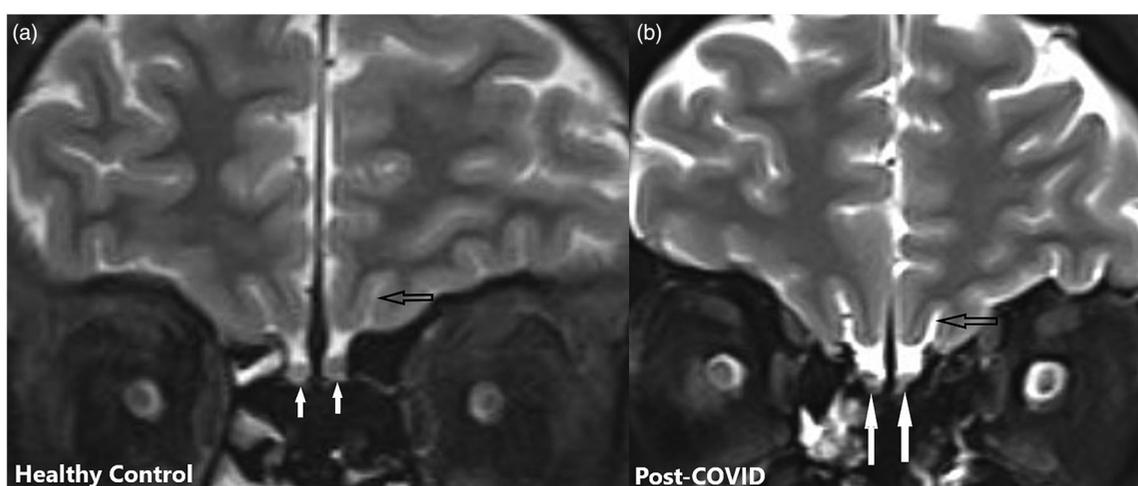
A healthy adult 43-year-old female case (a) and a chronic stage 49-year-old female COVID-19 case (b) in fat-suppressed coronal T2-weighted images with 3 mm slice thickness. The volume loss in the olfactory bulb and an increase in perineurinal CSF distances are also observed in the right image (b) (arrows). The shallowness of the olfactory sulcus is present similar to first case (hollow arrow).
